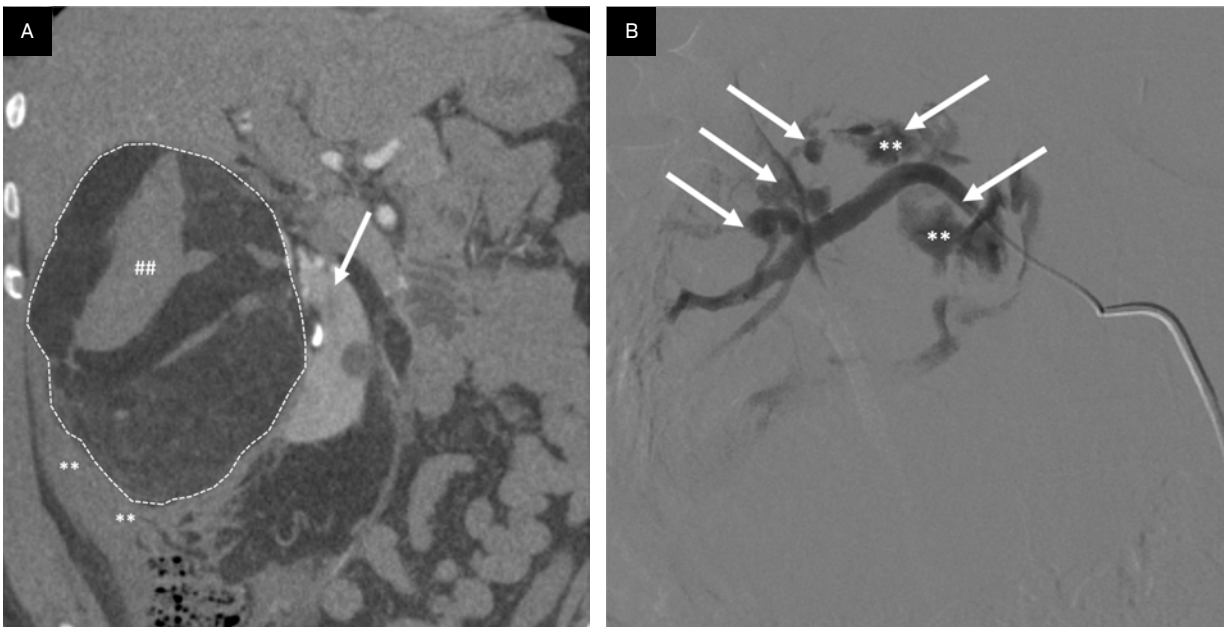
Angiomyolipoma (AML) rupture. AMLs > 4 cm or containing pseudoaneurysms > 0.5 cm have an increased propensity to bleed. (A) Coronal CT reformation through large, ruptured AML with macroscopic fat (dotted white lines outlining lesion) in the right kidney (arrow) with resultant perinephric hematoma () and internal hemorrhage (##). (B) Selective catheter arteriogram following AML rupture demonstrating multiple pseudoaneurysms (arrows), 2 with contrast extravasation indicating active hemorrhage ().
